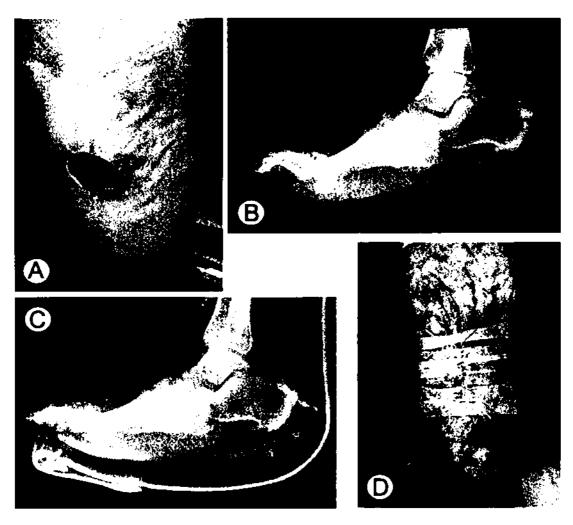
(A) This Charcot patient presented with a recalcitrant ulceration below an area of bony prominence, (B) as shown on radiograph. Surgical management consisted of excision of the ulcer, (C) exostectomy, and (D) primary wound closure.
